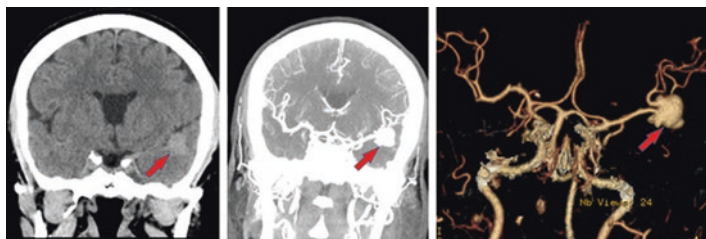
Non-contrast CT scan and CT angiogram showing left MCA aneurysm (red arrow)
